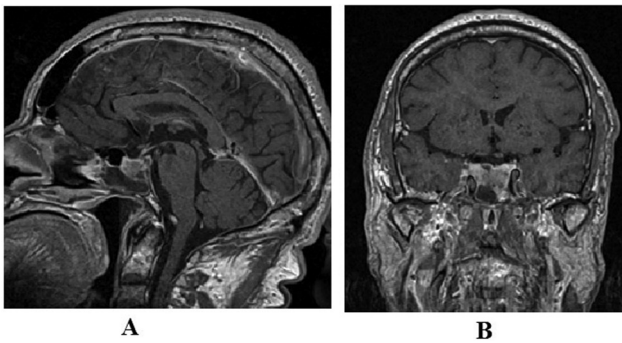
Endo-infra-sellar lesion of hypophyseal gland. MRI with contrast enhancement in sagittal view (A) and coronal view (B).
